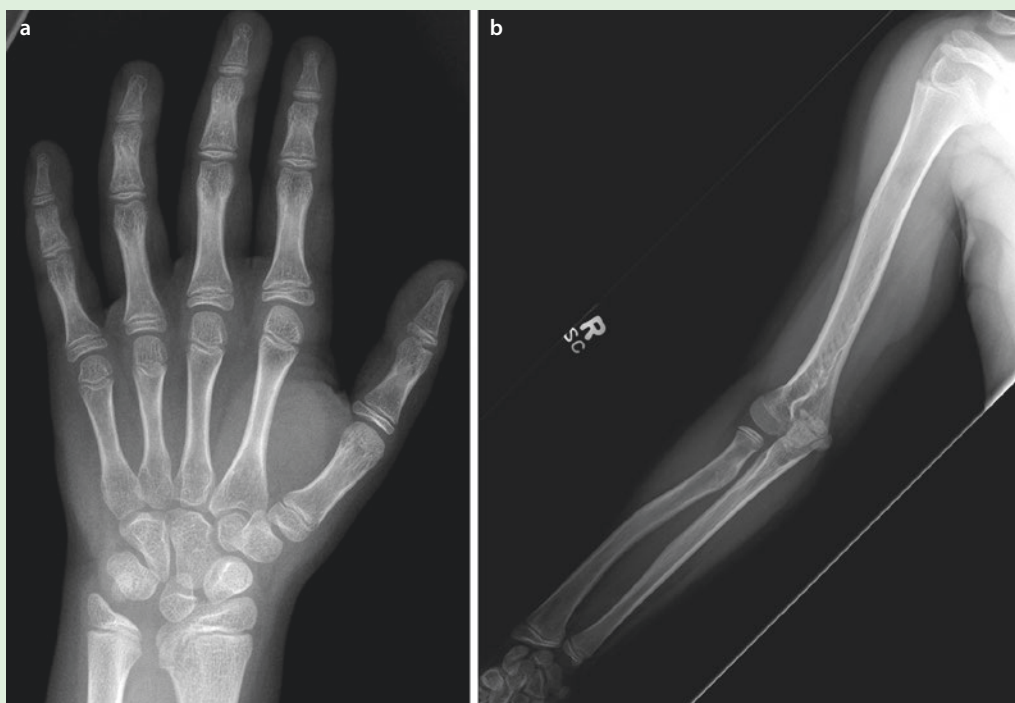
X-rays for case 1, a 10-year-old girl with short stature. *Panel a* shows the left hand/wrist film obtained for a bone age. The growth plates of the radial and ulna heads are abnormal, particularly at the medial borders. These abnormal growth plates cause the articular surfaces of these bones to grow
